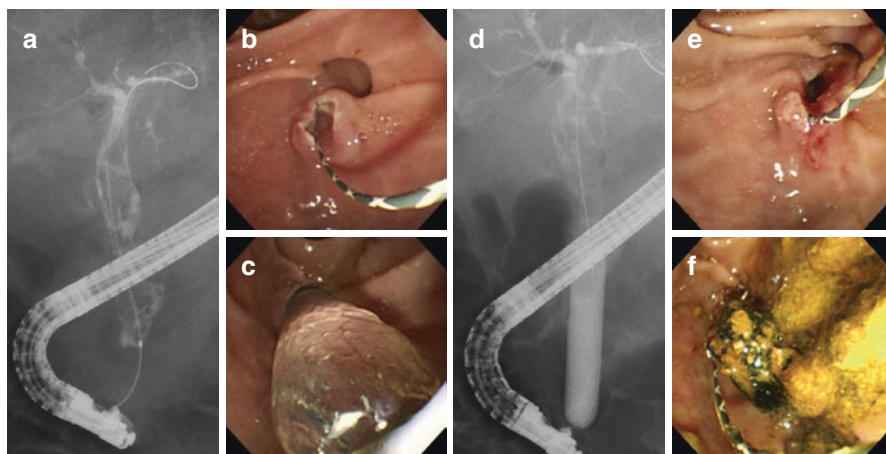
Endoscopic papillary large balloon dilatation (EPLBD) technique. (a) Cholangiogram showed large and multiple bile duct stones. (b) Endoscopic sphincterotomy (EST) was performed. (c) Papillary dilation with large balloon. (d) X-ray showed large balloon expanded. (e) Large biliary orifice can be seen after balloon deflation. (f) Large bile duct stone removal without crush
